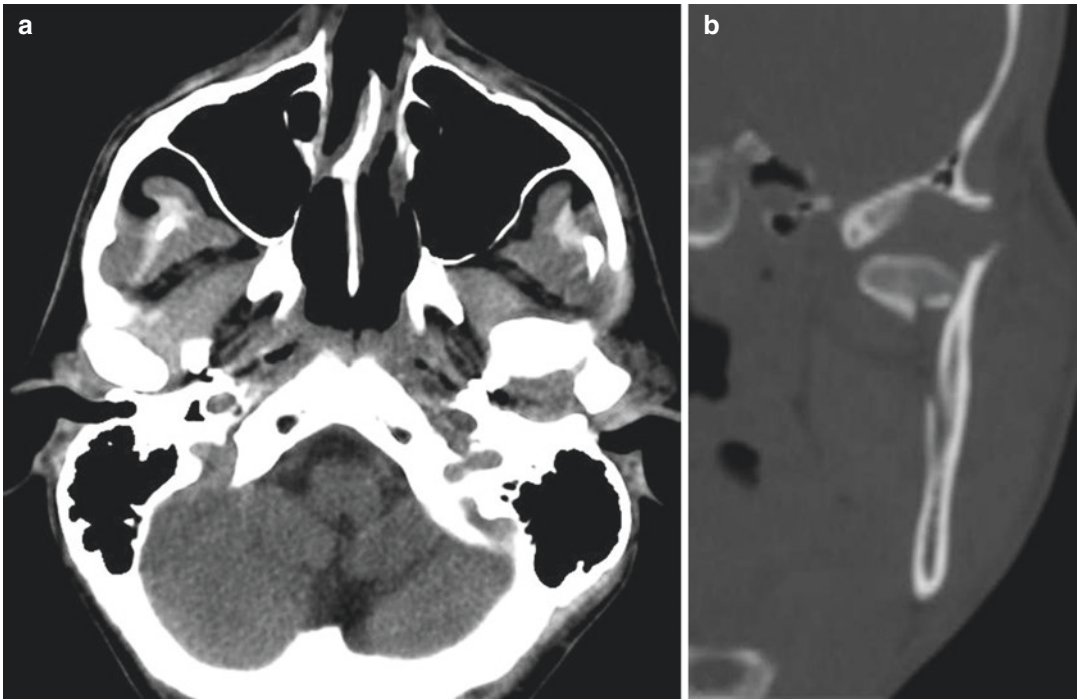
Mandibular condyle should be always given attention on brain CT scan. In that case the radiologist noted displacement of the left condyle (a) and completed the examination with maxillofacial CT (b) that confirmed diagnosis of a displaced fracture
